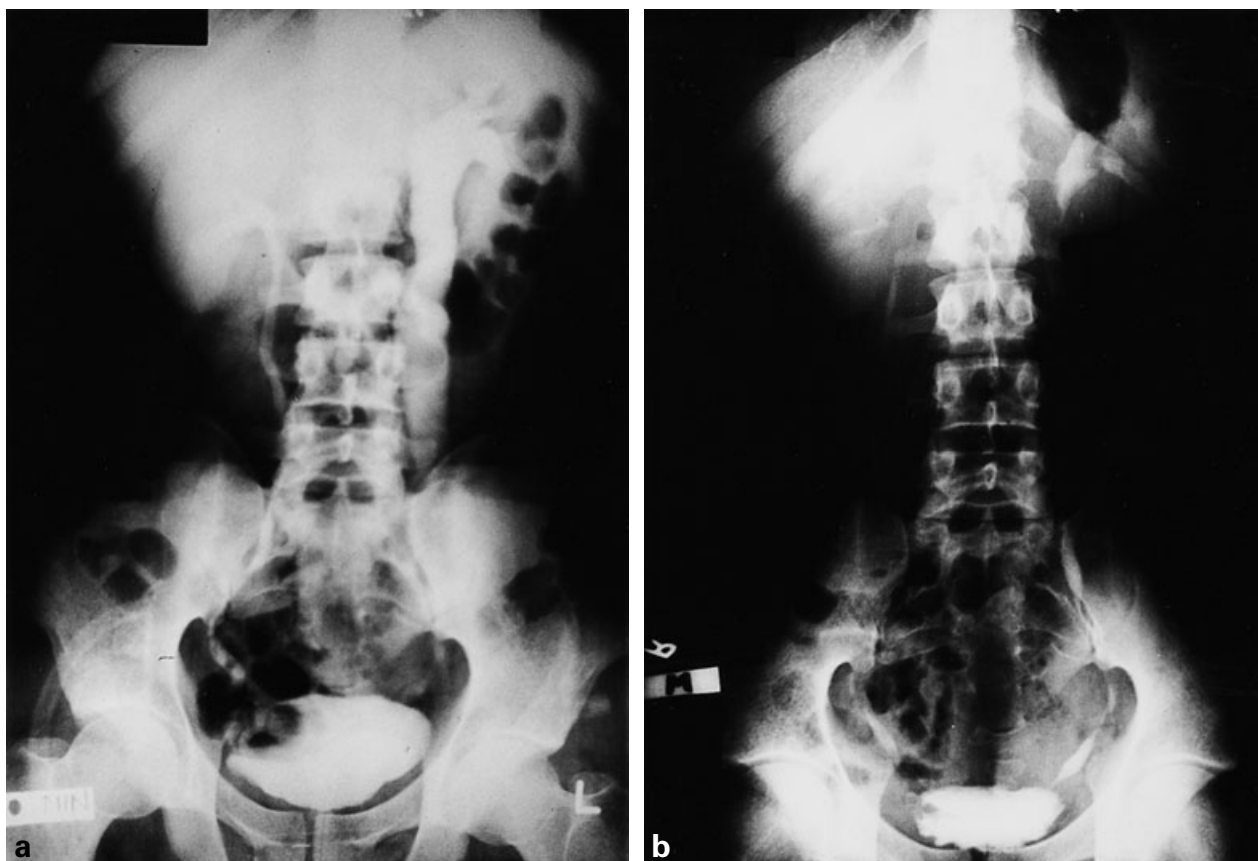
a, Dilatation and apparent obstruction of the left upper tract as seen on the supine excretory urogram. b, The post-micturition erect radiograph shows excellent drainage of the left upper tract. The filling defect on the right side of the bladder shows that the radiographs are from the same patient.
